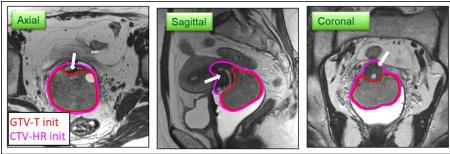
Delineation of CTV T HR init. Pelvic T2w FSE MRI in a patient with an exophytic cervical cancer, FIGO stage IB3. Representative slices in 3 main orientations are shown. Gel was injected into the vagina to improve depiction of the regions of interest. The tumor is in the caudal aspect of posterior lip of the portio. Delineation of CTV T HR init encompasses the GTV T init (high-signal intensity lesion) and the remaining normal appearing cervix (white arrows), without additional margins. Note the conical shape of the cranial cervical border – compare with Figure 3 and 4.
